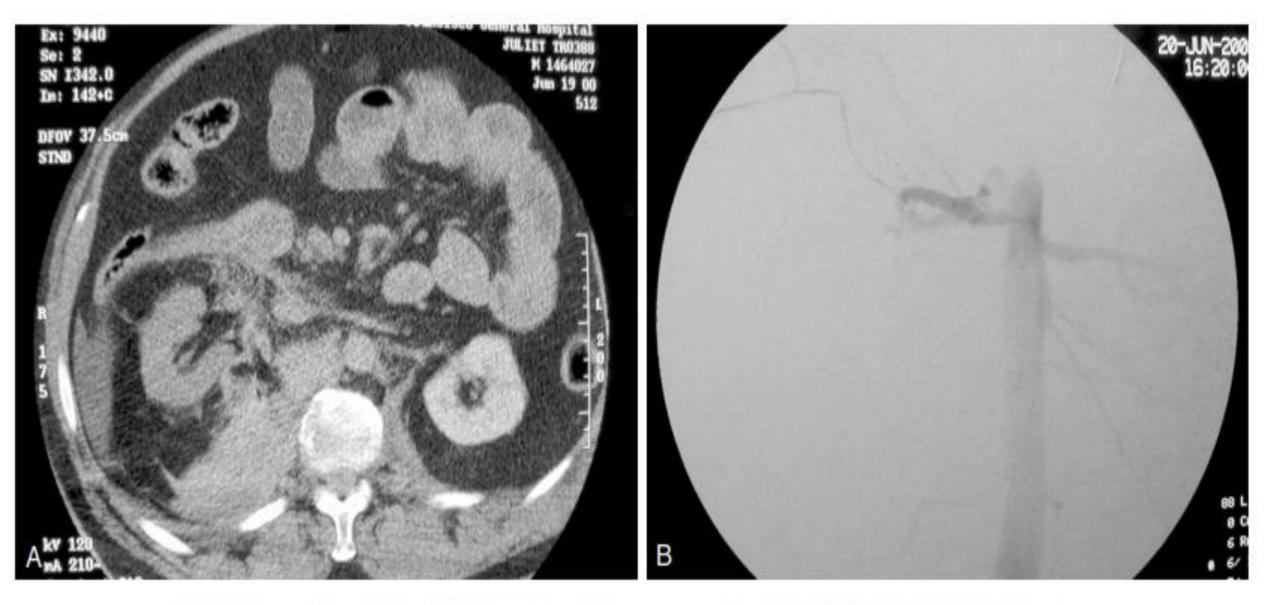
(A) CT scan showing right renal artery thrombosis after crush injury. Note poor contrast uptake in right kidney compared with left and diffuse soft tissue injury medial to right kidney in the area of the renal artery. (B) Angiogram showing right renal artery thrombosis after crush injury.
